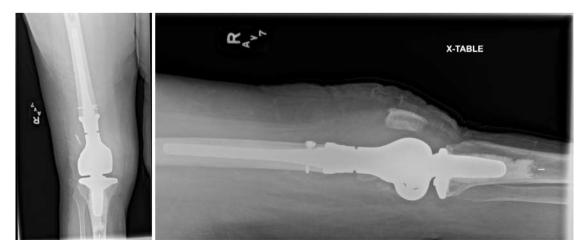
Anteroposterior and lateral radiograph of the right knee after operation.
